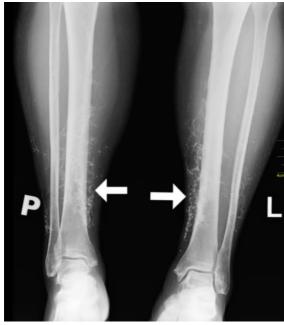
X-rays of the shin with symmetrical subcutaneous disseminated reticular saturated calcifications on the crura.
